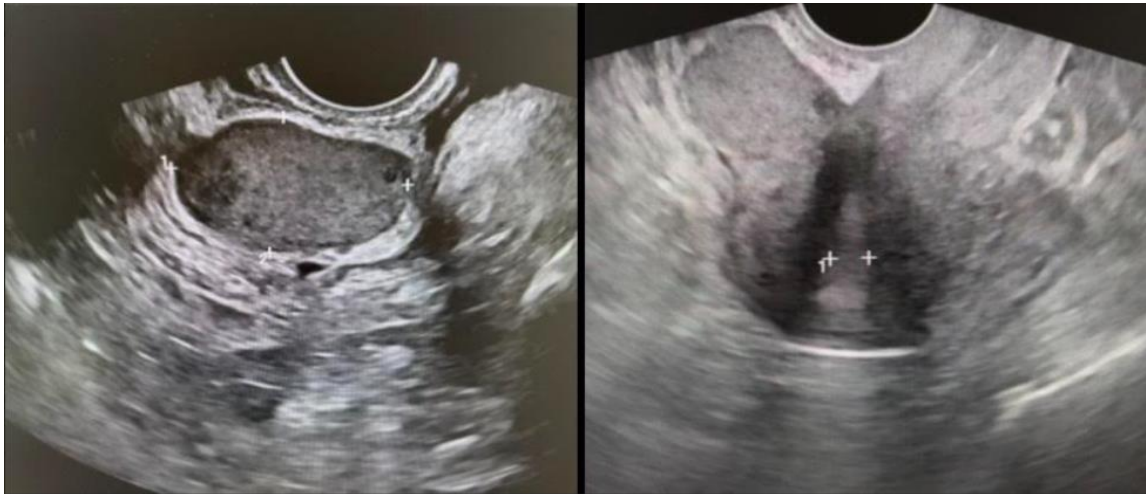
Transvaginal ultrasonography demonstrating a well-defined heteroechoic lesion at the cesarean scar site, extending from the anterior uterine wall toward the serosa. The lesion appears relatively homogeneous with low internal vascularity on Doppler evaluation. These findings were initially interpreted as suggestive of scar endometriosis; however, subsequent surgical exploration revealed a chronic abscess.
